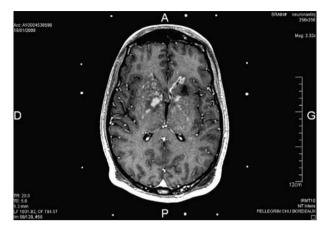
Diffuse periventricular enhancement on T1-weighted sequences after IV Gadolinium infusion
